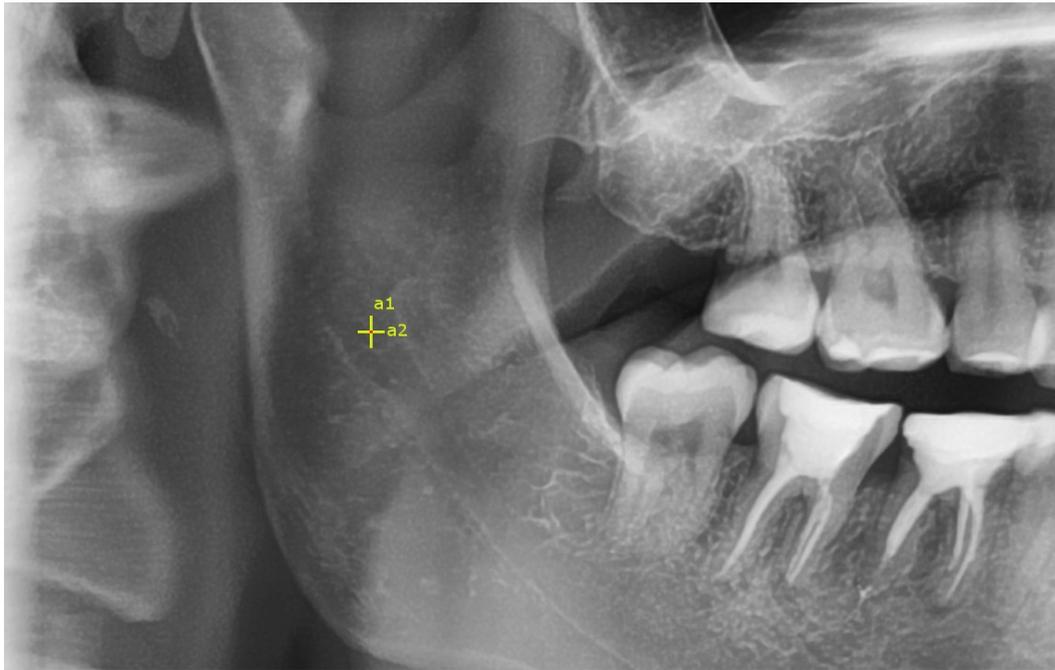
An example of a panoramic radiograph with the method of measure for width and height of the foramen.
